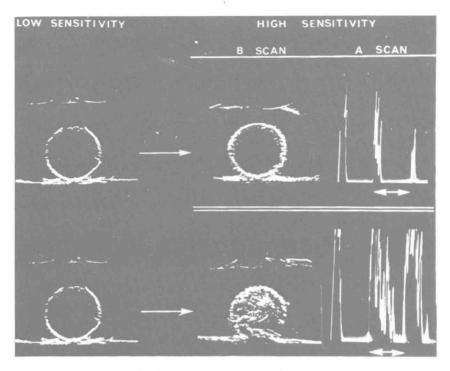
Differentiating cysts (top) and solid tumors (bottom) by altering power of ultrasonic beam. (Reproduced by permission from Lyons EA, Murphy AV, Arneil GC: Sonar and its use in kidney disease in children. Arch Dis Child 47:777, 1972.)
